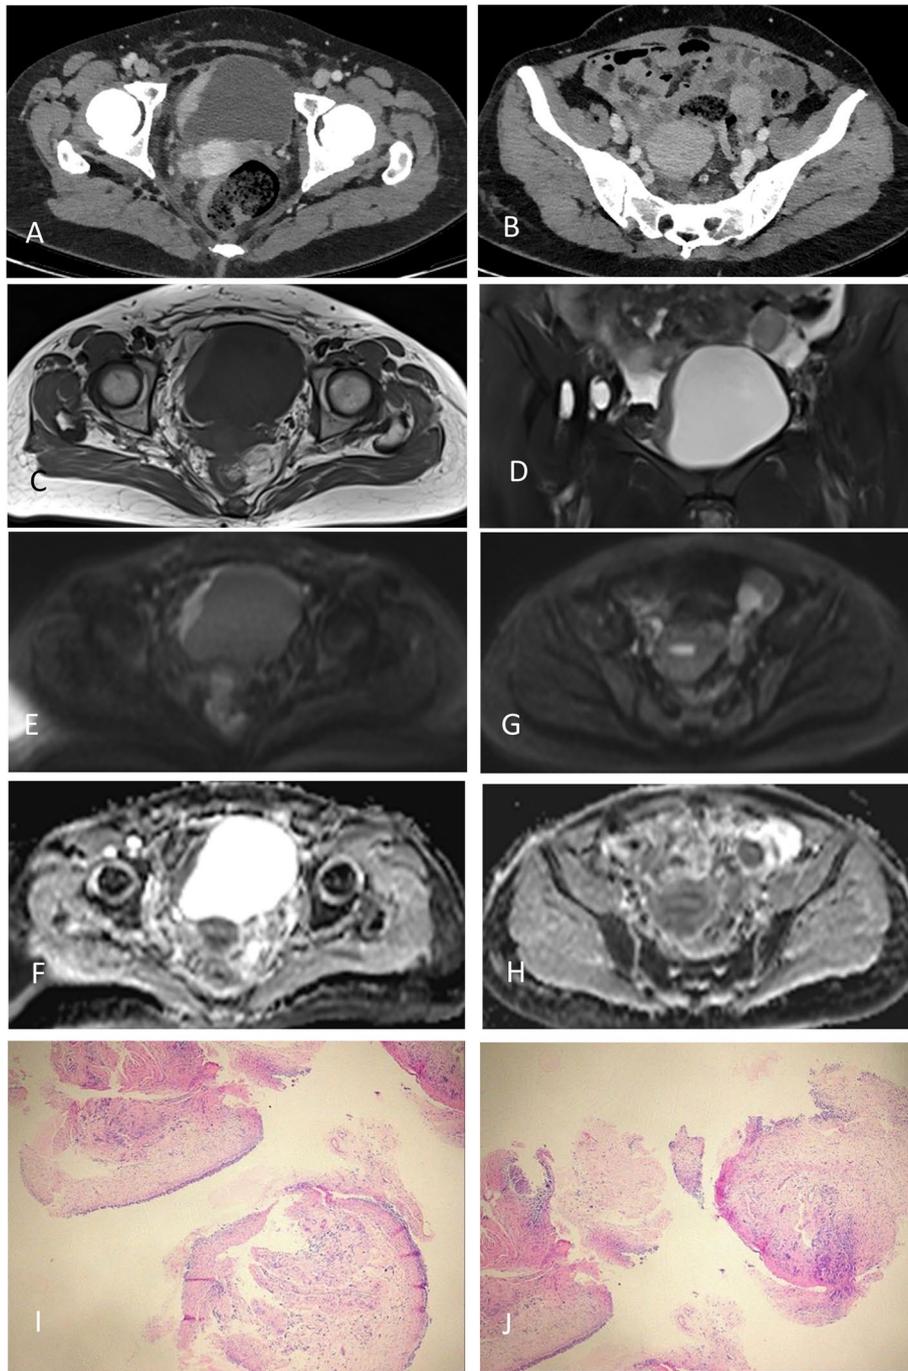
CT urography showed local thickening and delayed enhancement of the right wall of the bladder (A), and mildly enhancing nodule in the left adnexal area (B). Pelvic MR showed localized thickening of the right lateral wall of the bladder with low signal on T1WI (C), high signal on T2WI (D), and limited diffusion in DWI (E, F). Solid nodules in the left adnexal area with slightly higher signal on T2WI (Fig. 1D), restricted diffusion in DWI (G, H). The pathological results of cystoscopy biopsy showed that (I, J) the surface of the tissue was covered with transitional epithelial cell, fibrous tissue hyperplasia in the lamina propria of the mucosa. Atypical cells were seen in the tissue, these cells had a small volume with ovoid nuclei and basophilic cytoplasm, and were arranged in nests, sheets, and diffusely
